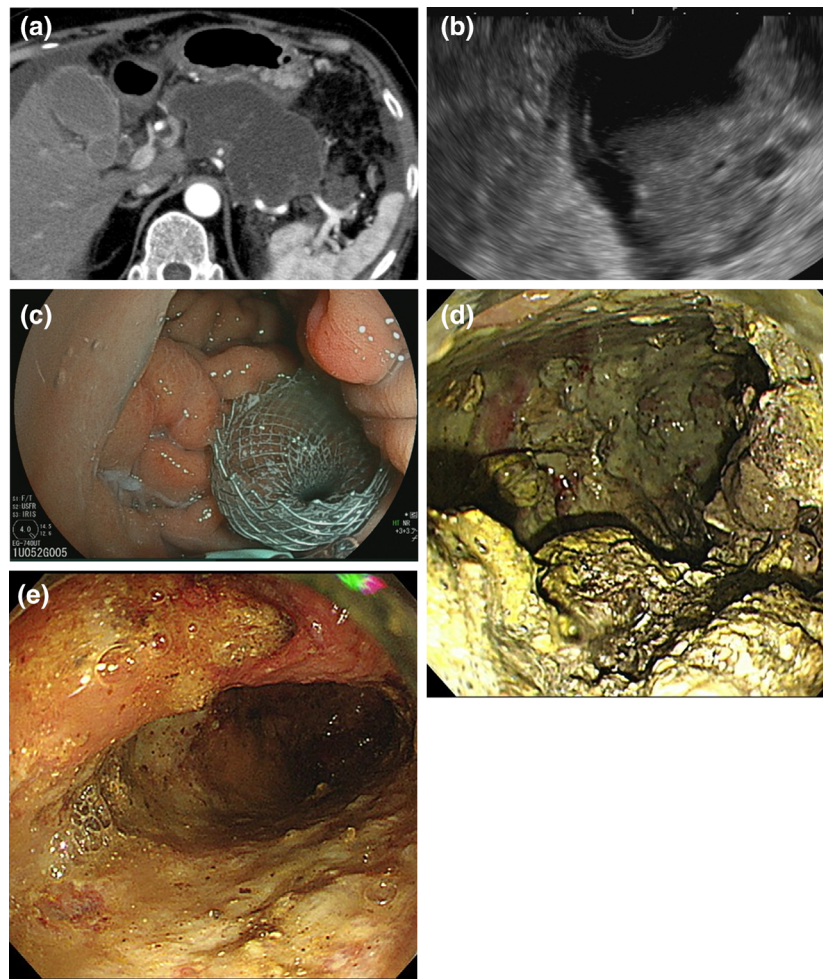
Endoscopic treatment of walled-off necrosis (WON). (a) Computed tomography image of WON. (b) Endoscopic ultrasonography image of WON with fluid component and necrotic tissues. (c) A lumen-apposing metal stent (LAMS) placed for WON. (d) Direct endoscopic necrosectomy (DEN) through the LAMS, showing a large amount of necrosis. (e) Endoscopic images of WON after successful DEN.
